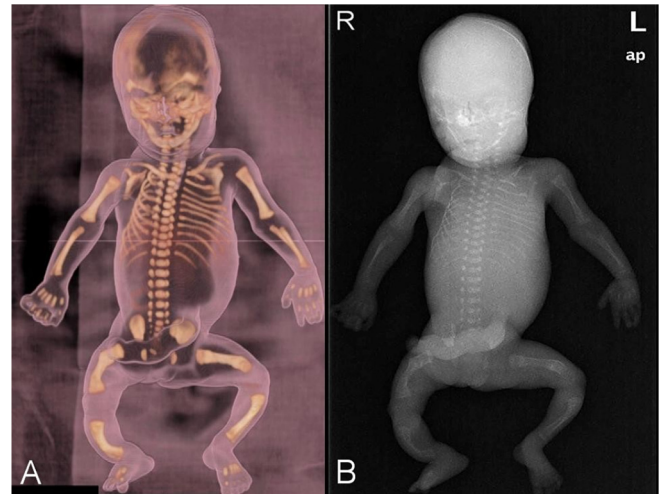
Case 2. (A) *Post mortem* computed tomography plus three-dimensional reformatting and (B) radiography showed arched shape of the long tubular bones, with morphology handset. The thorax was characterized by dysmorphic ribs, with asymmetry of the rib cage. In addition, minimum attitude in subluxation of the fifth ray of the right hand was also observed.
